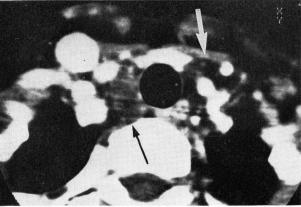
Neck CT shows two cystic masses which were not accurately indentified preoperatively. The black arrow indicates a right parathyroid cyst accompanied by an oxyphilic adenoma, and the white arrow reveals a left parathyroid cyst
